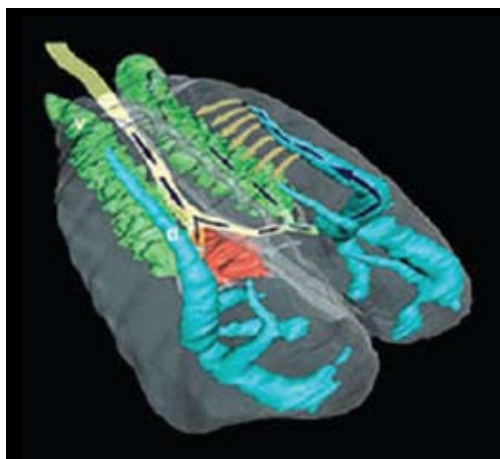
Image of CT scan of American alligator courtesy of C. G. Farmer
